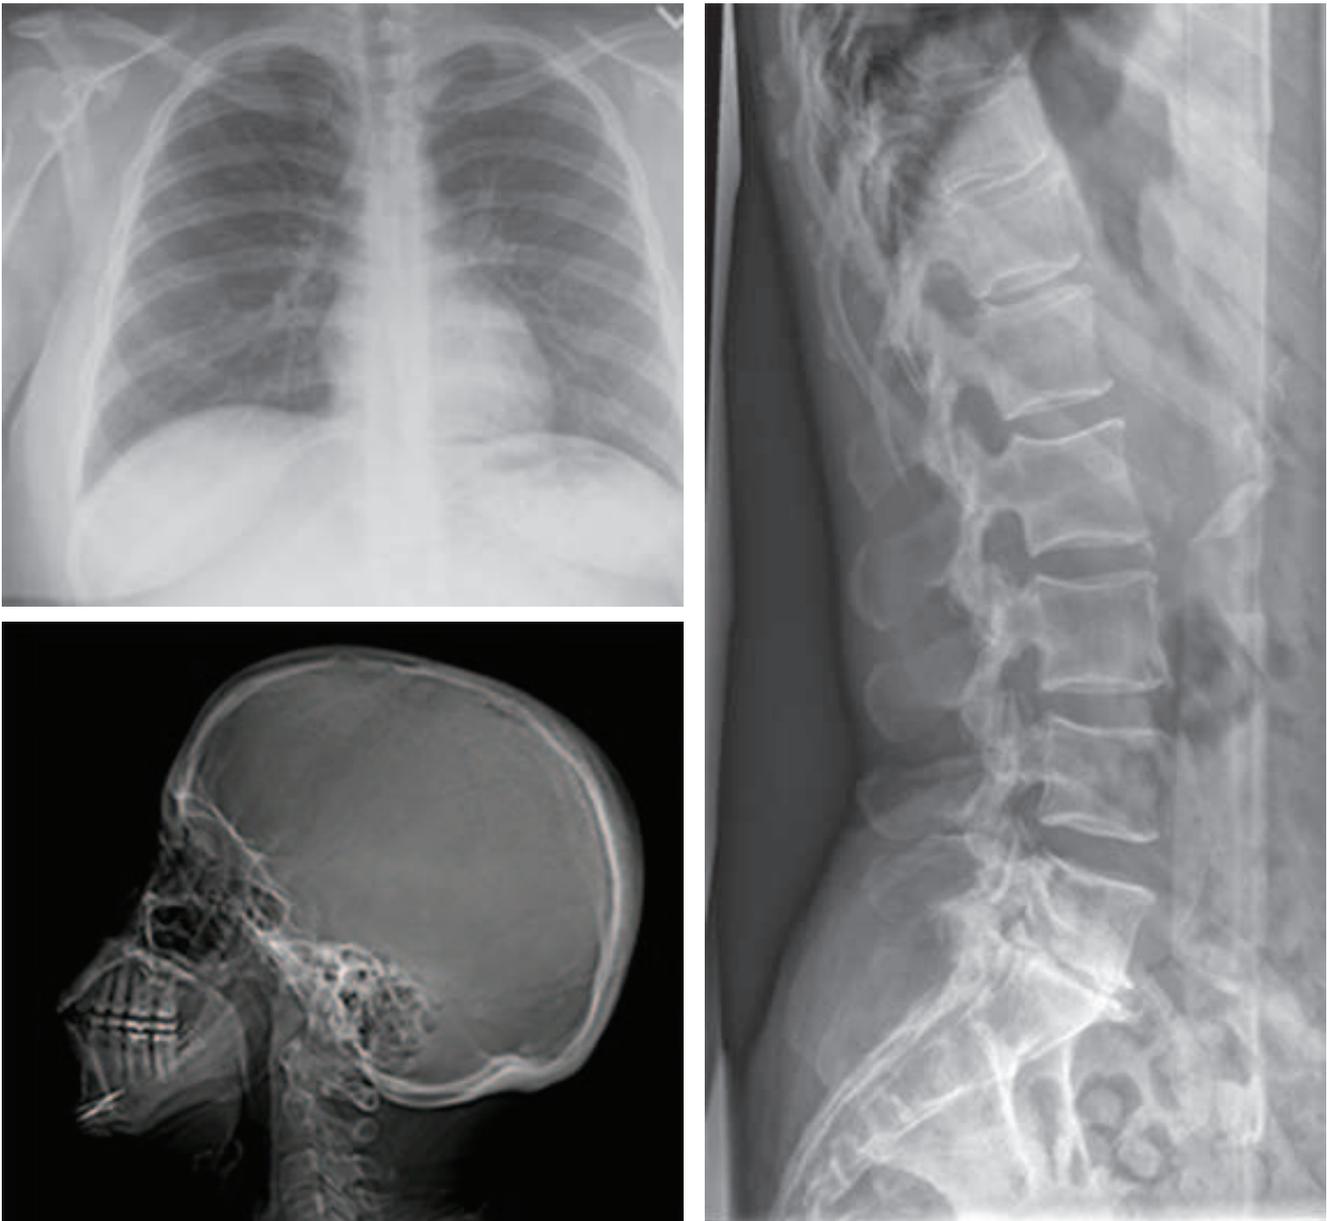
X-ray chest, skull and lumbo-sacral spine.
